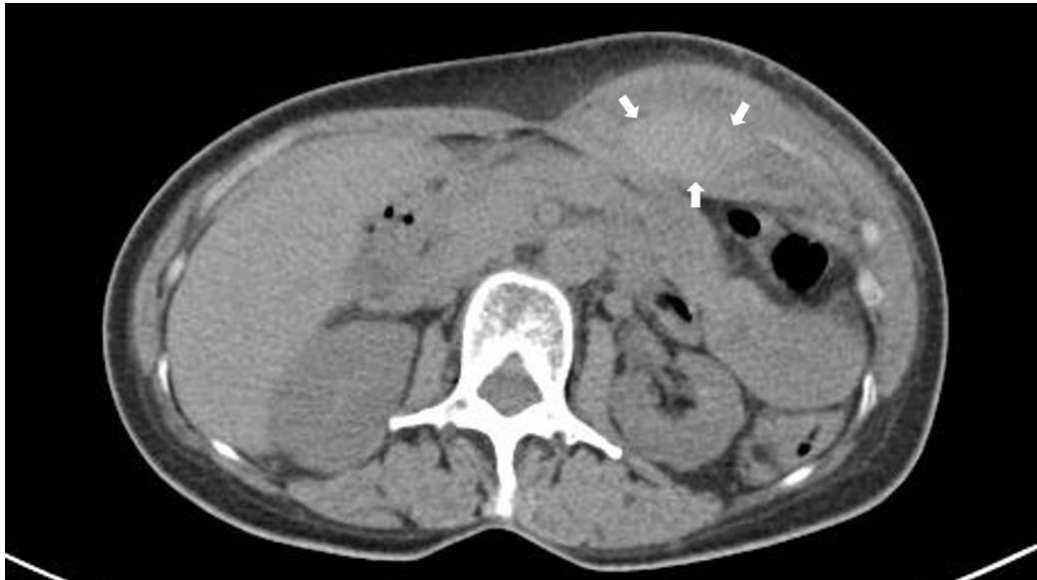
Axial view of patient's abdomen computed tomography revealed a rectus hematoma
